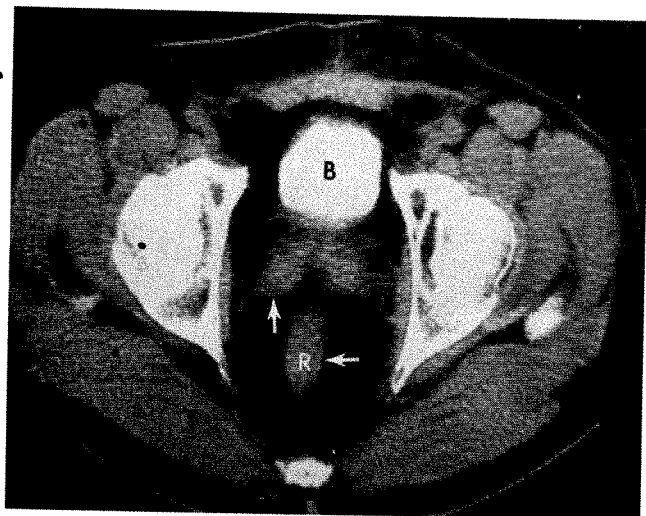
CT scan of normal pelvis in 75-year-old man. Opaque bladder (B) filled with contrast media sharply delineated by surrounding peripelvic fat. Seminal vesicles (vertical arrow) seen on either side posterior to bladder. Rectum (horizontal arrow; R) clearly demarcated by surrounding fat.
